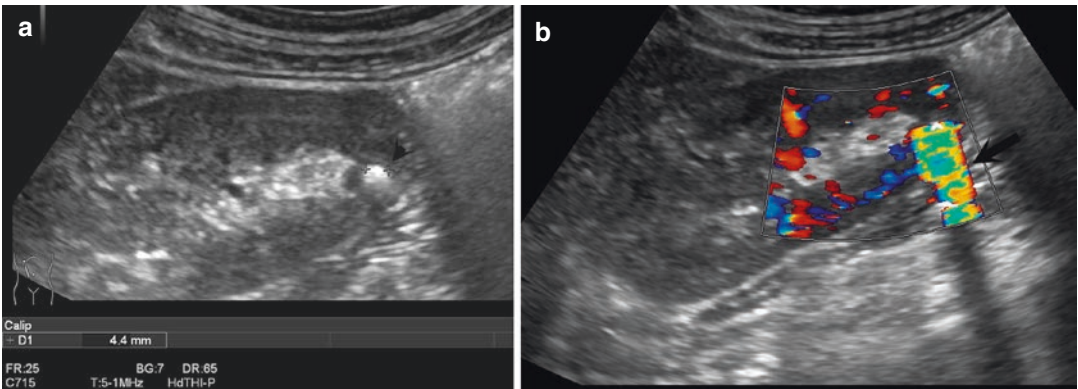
Renal stone. In (a), the stone is identified as hyperechogenic foci with posterior shadowing (arrowheads). Using color Doppler (b), the stone produces the twinkling artifact, a mixture of red and blue pixels (arrow)
